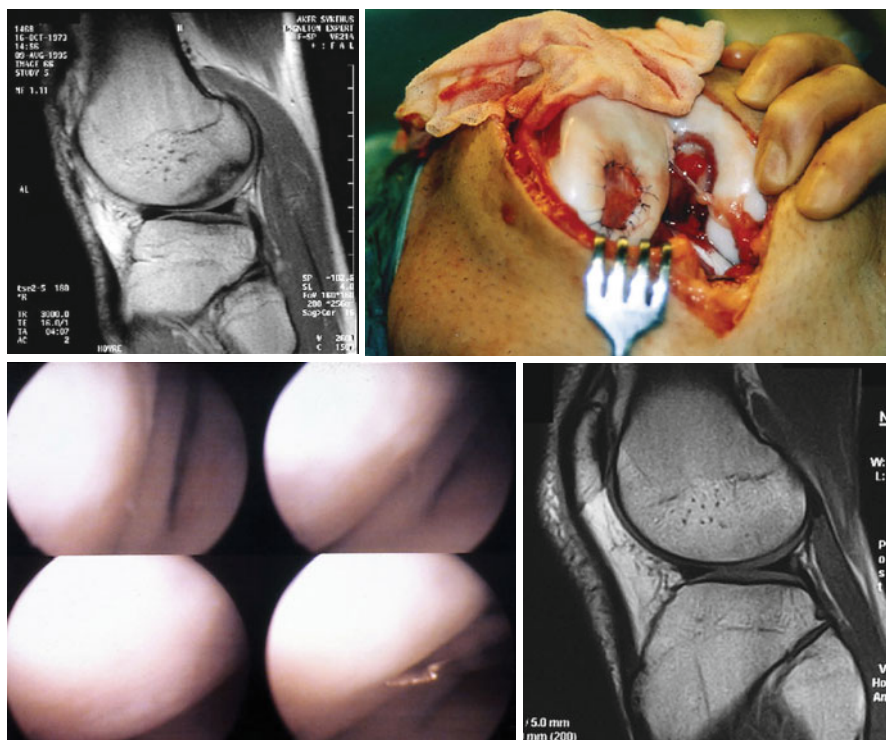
Osteochondritis dissecans treated with ACT/ACI is one of the best treatments reported. *Upper row, left:* preoperative MRI showing large and deep OCD of lateral femoral condyle in 24 year old soccerplayer. *Upper row right:* showing the defect at surgery. *Lower row, left:* second look arthroscopy at 1 year, returned to professional football (*soccer*) at 15 months and are still playing at age 38. *Lower row, right:* MRI 9 years after surgery showing complete healing of both bone and cartilage
